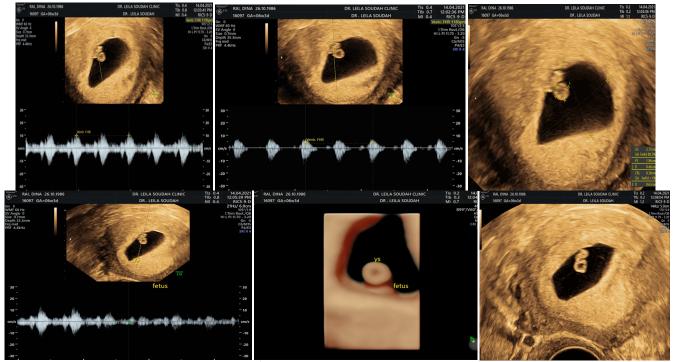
8th Gynae ultrasound; 6+5 weeks of pregnancy
